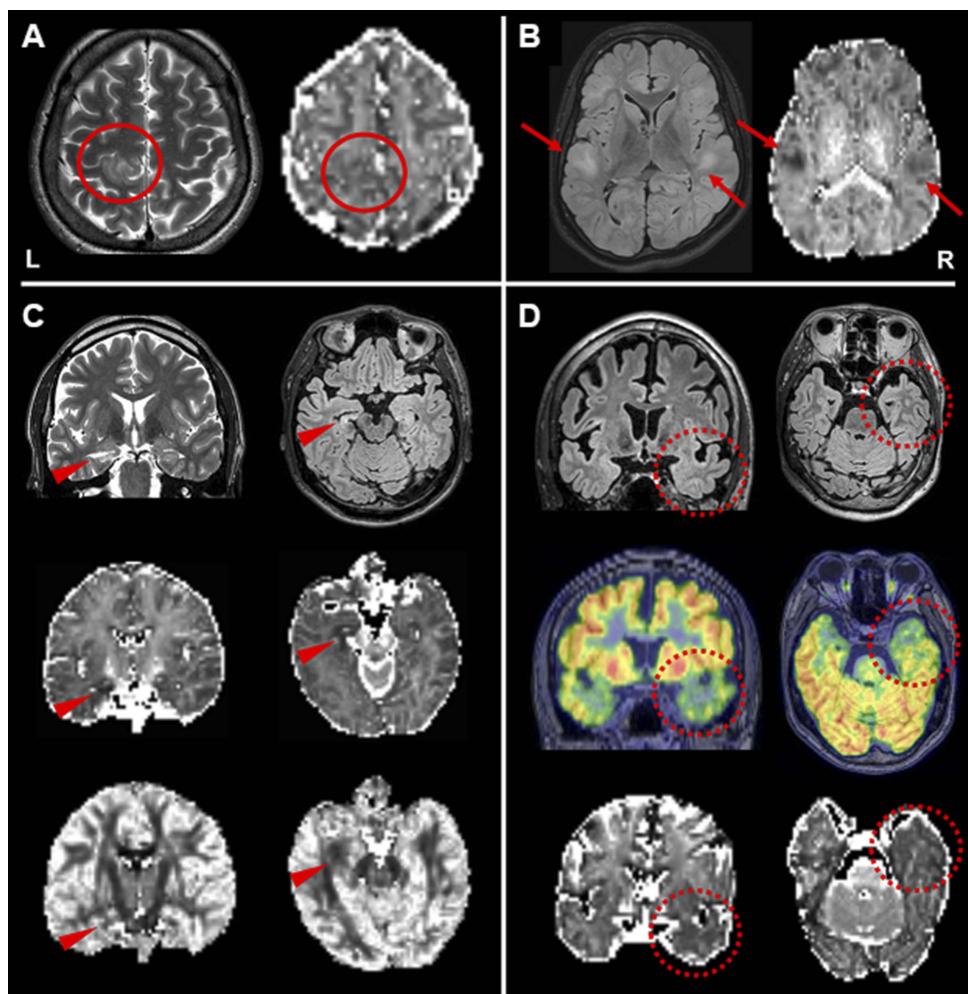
(A) In a 46-year-old patient with focal epilepsy, reduced neurite density is evident in the focal cortical dysplasia (circles). (B) A 17-year-old patient with tuberous sclerosis. Reduced neurite density can be seen in the multiple cortical tubers (arrows). (C) A 37-year-old patient with left temporal lobe epilepsy and hippocampal sclerosis. The abnormal hippocampus shows reduced neurite density and orientation dispersion (arrowheads). (D) A 47-year-old patient with right temporal lobe without any visible lesions on conventional MRI. The right temporal lobe shows reduced neurite density in accordance with the hypometabolic areas of ^{18}F -FDG-PET (broken circles).
